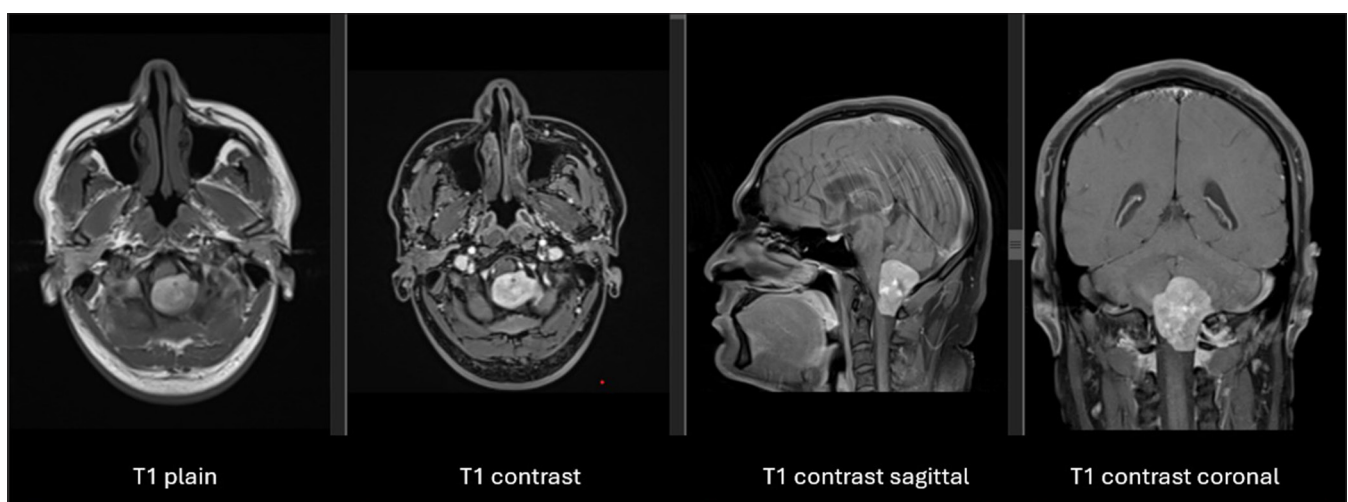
Magnetic resonance imaging showing extra-axial lesion at the level of foramen magnum.
